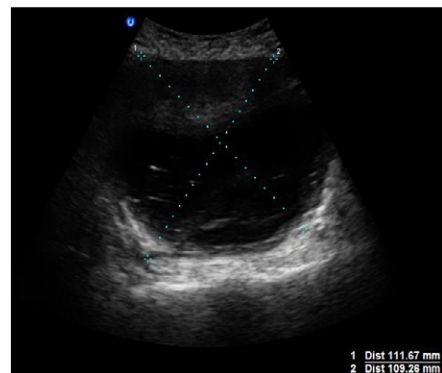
Ultrasound showing an echogenic mass (hematoma) of 111 mm.
